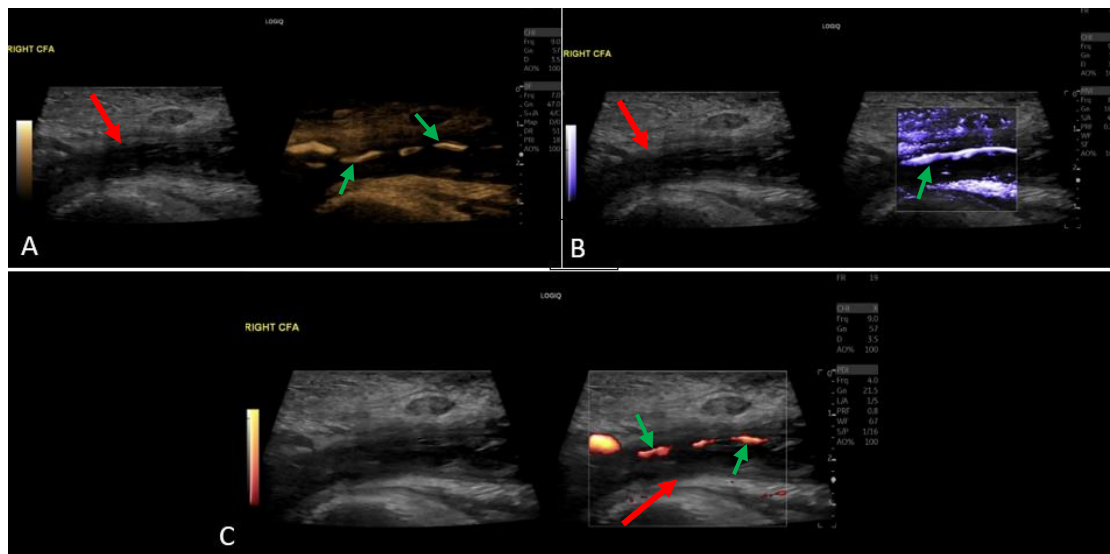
Partially thrombosed CFV with hypoechoic thrombus (red arrows) in longitudinal plane. CEUS in A (right), SMI in B (right) and Power doppler in C (right) techniques depicting low-velocity blood flow in the periphery of the partially thrombosed lumen (green arrows).
